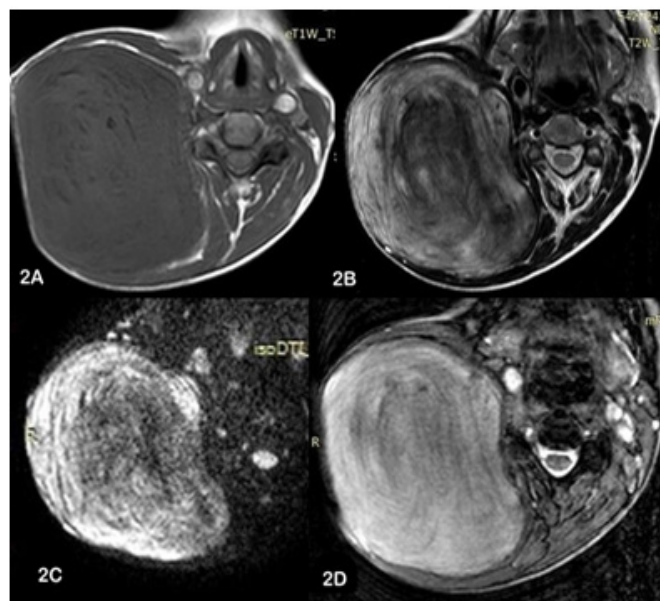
Magnetic Resonance Imaging (MRI) showing heterogeneous signal intensities with whorl appearances in T1 weighted (2A) and T2 weighted (2B) images with areas of diffusion restriction (2C) without any GRE blooming (2D).
